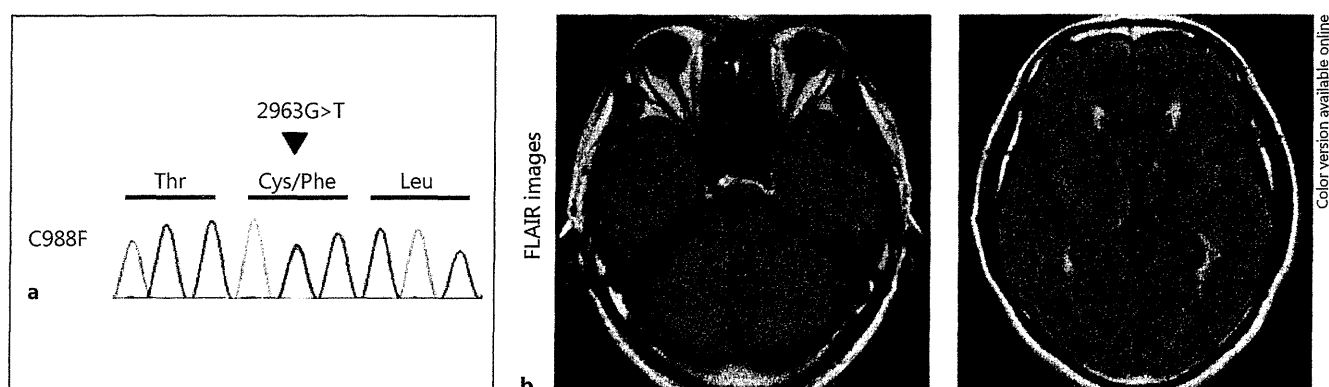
a Genetic testing revealed p.Cys988Phe (C.2963G>T) mutation in exon 18 of the patient's *NOTCH3* gene. b FLAIR imaging at 51 years of age showed the anterior temporal poles and the external capsules appeared relatively sparse in this case as compared with typical findings of CADASIL.
